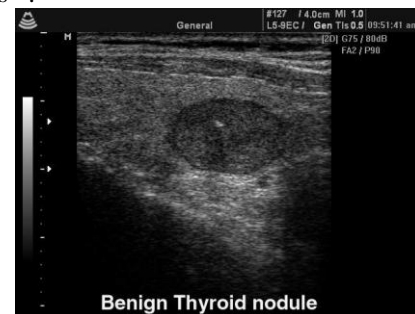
Ultrasound Showing Thyroid Nodule
